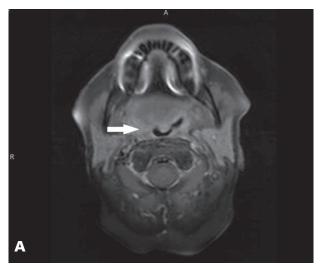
Magnetic resonance images (MRIs). A. T1-weighted MRI shows obliteration of the right piriform sinus, suggestive of a mass effect by a tumor at the base of the tongue (arrow). B. T2-weighted MRI of the brain reveals an enhancing lesion (arrow) in the right
